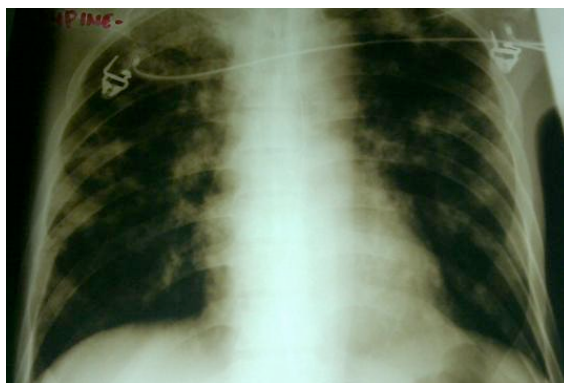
Chest x-ray showing multiple soft fluffy shadows with pleural thickening.
